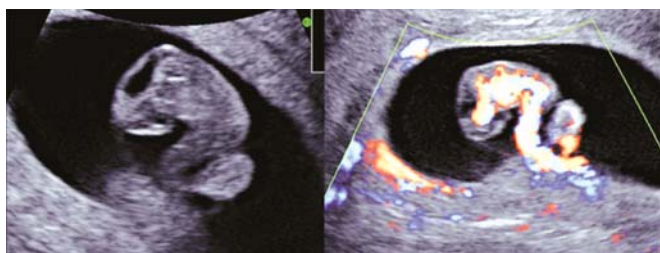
Early cranial circulation at 7 weeks of gestation. Left upper shows B-mode image of sagittal section and right figure shows fetal circulation by bidirectional power Doppler technology
